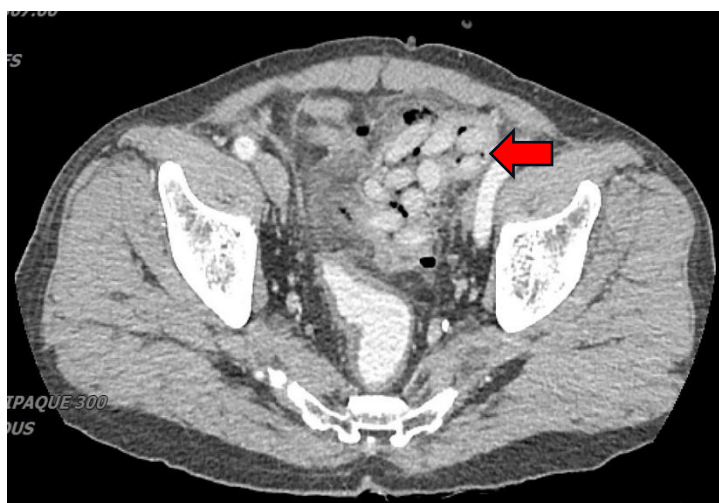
CT showing multiple ovoid structures within the lumen of the proximal sigmoid and descending colon
